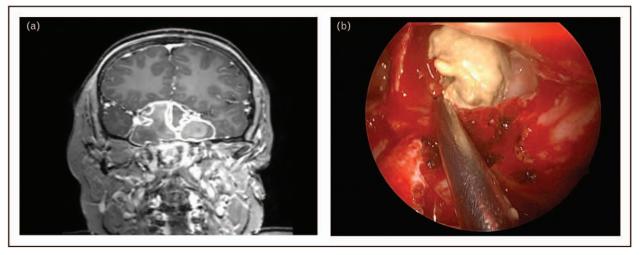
16-year-old female with severe allergic fungal sinusitis seen on MRI (a) found to have eosinophilic mucin and fungal debris in the left sphenoid sinus during endoscopic surgery (b).
